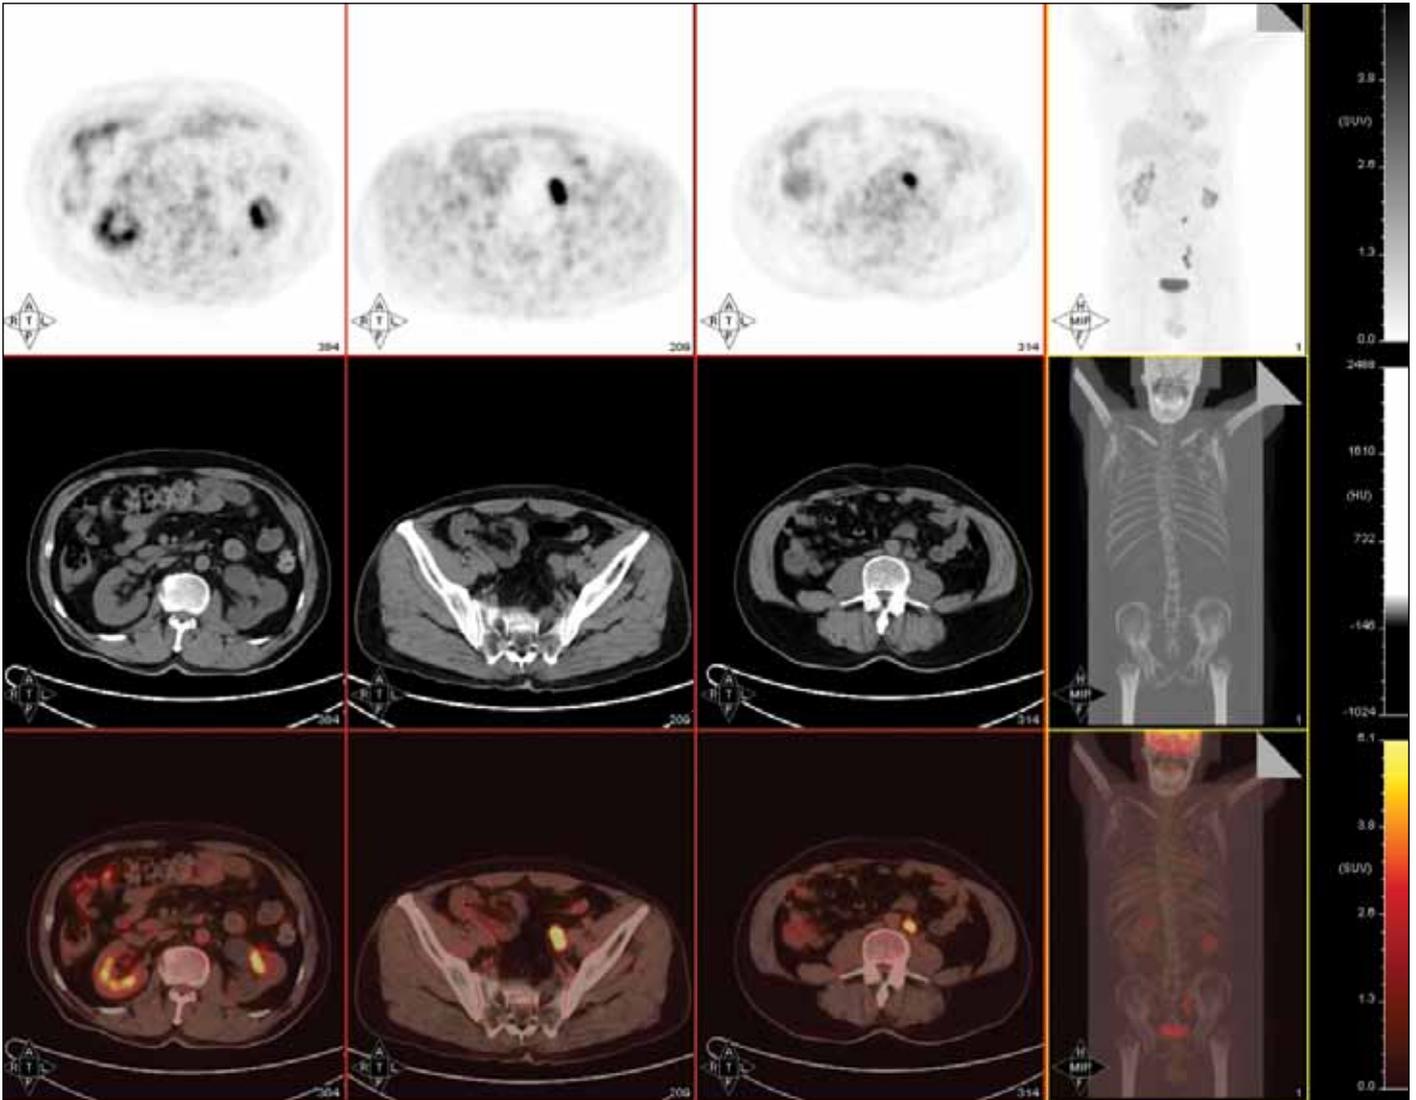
Positron emission tomography-computed tomography confirms the tumours in the left renal pelvis and ureter and suggests cancer metastasis in the swelling para-aortic lymph node.
